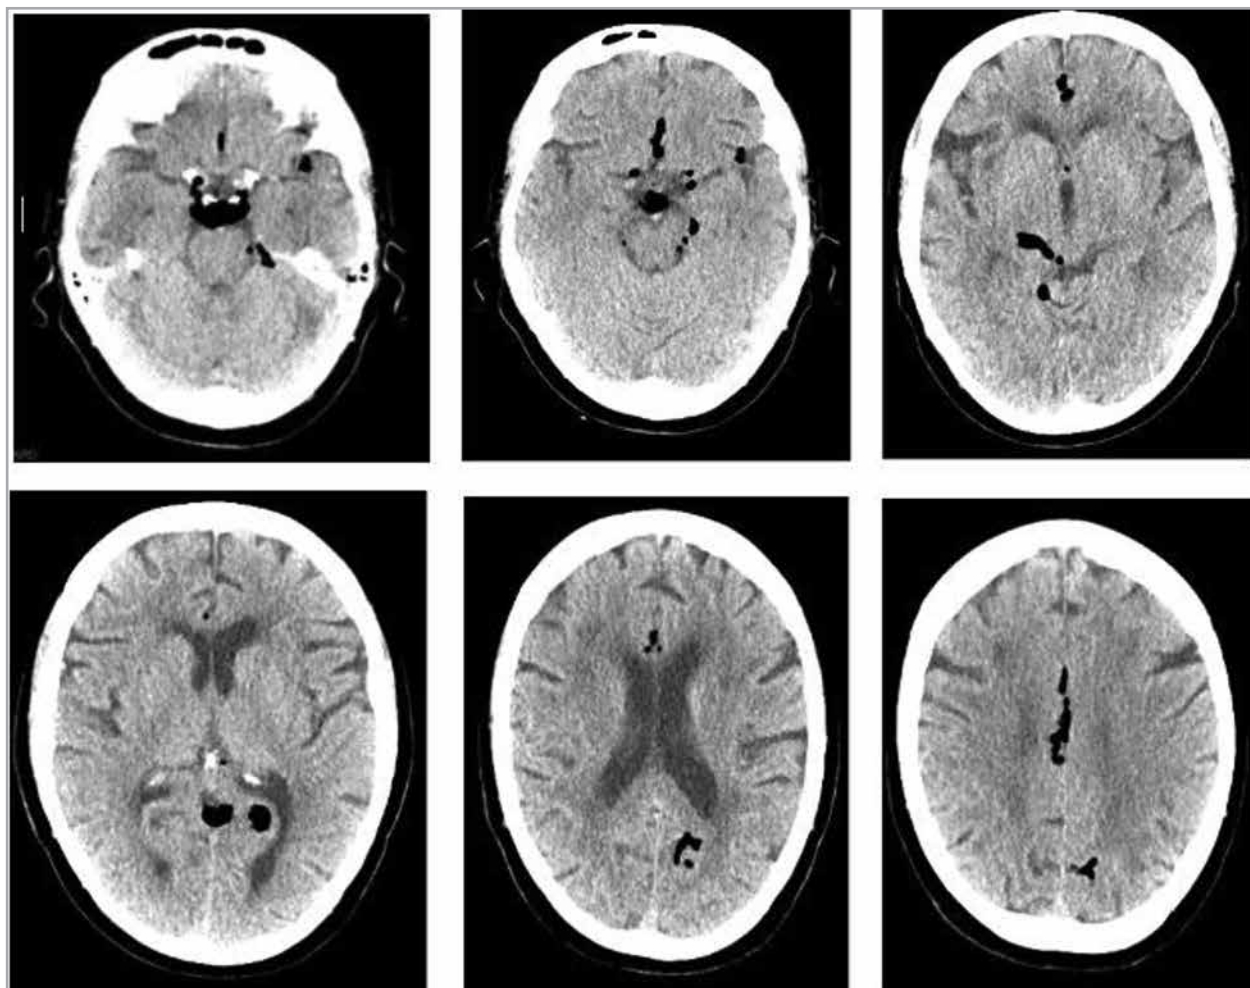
Select axial slices from noncontrast CT head performed during ED course, which demonstrate the finding of pneumocephalus.
